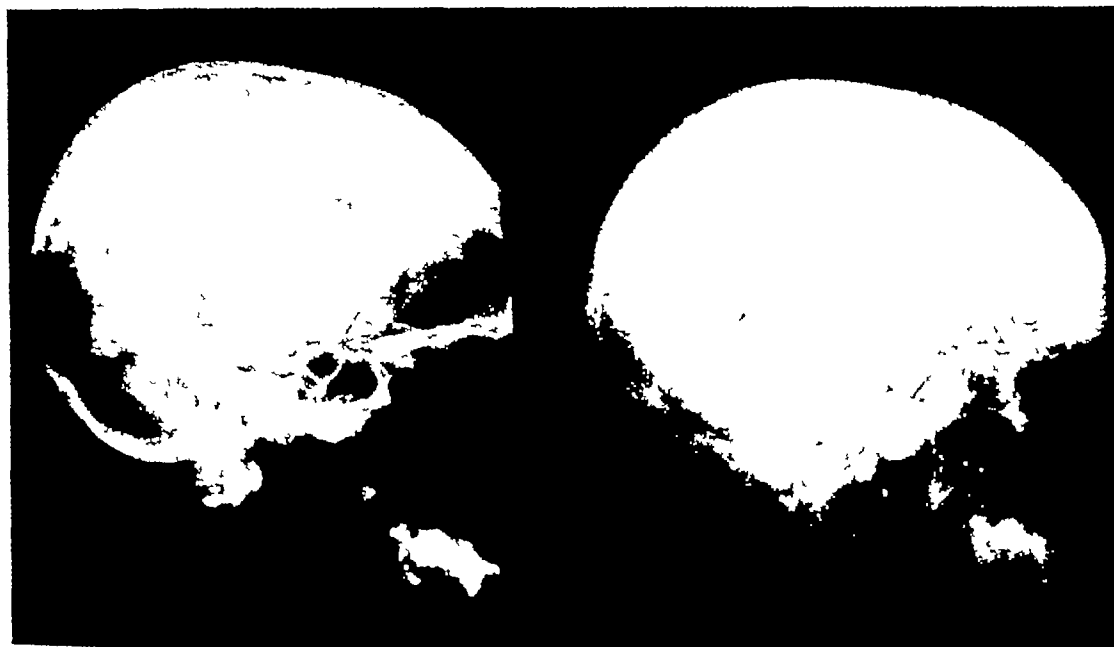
Skull metastasis from cancer of the breast before and after sterilization by x-rays
